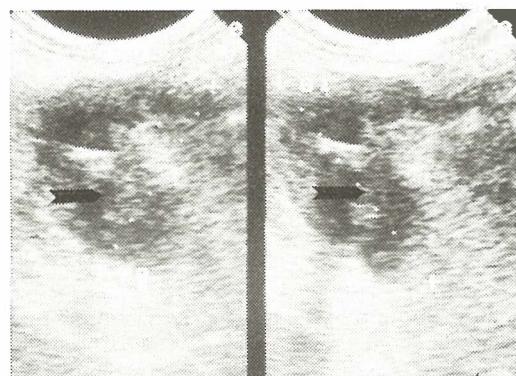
Cross-section of ultrasound scan of cecum cancer (arrows)
